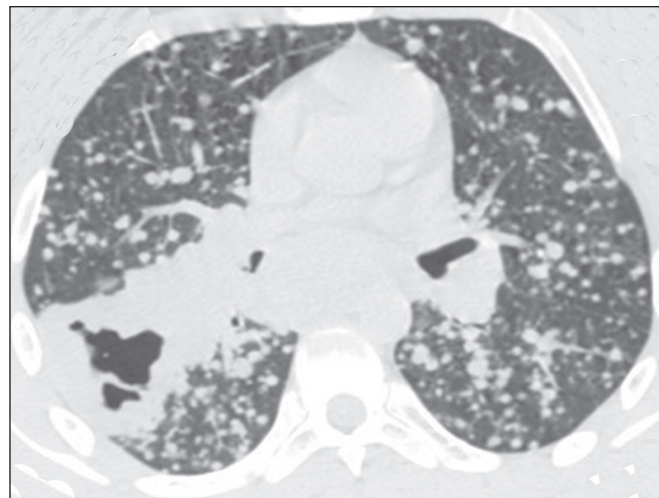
CT of a 29-year-old man, showing a cavitary mass, with internal septation, in the right lower lobe, together with multiple nodules disseminated throughout the lungs. Note also the lymph node mass in the subcarinal region.
